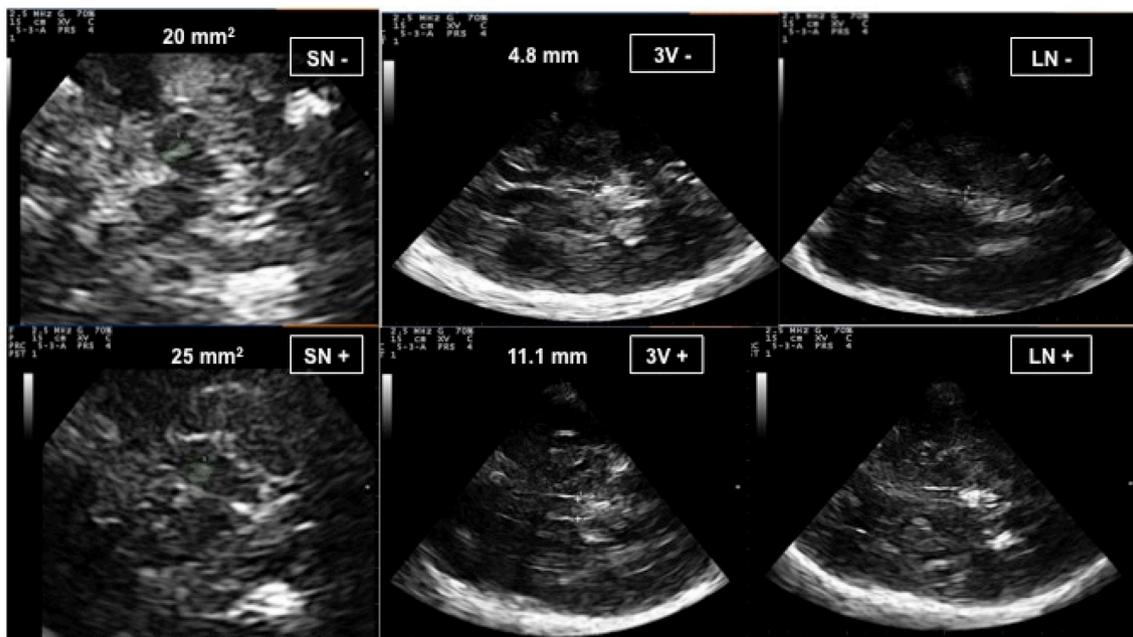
Ultrasound images showing normal and abnormal scans of substantia nigra echogenicity, third ventricle amplitude and lenticular nucleus echogenicity (Esaote MyLab25Gold). 3V: third ventricle, LN: lenticular nucleus, SN: substantia nigra.
